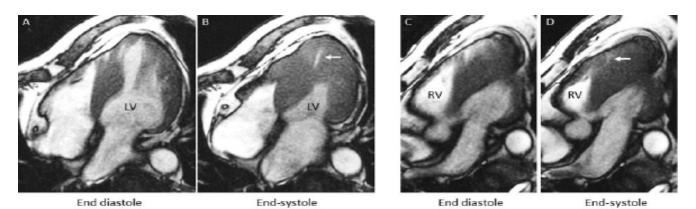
Magnetic Resonance Imaging: Four-chamber apical cine images at the end-diastolic phase show myocardial hypertrophy of the interventricular septum of the mid left ventricle (A), together with an apical chamber at the end-systolic phase (B, arrow). On the cine image focused on the right ventricular apex (C), a small apical chamber is also present at the end-systolic phase (D, arrows).
